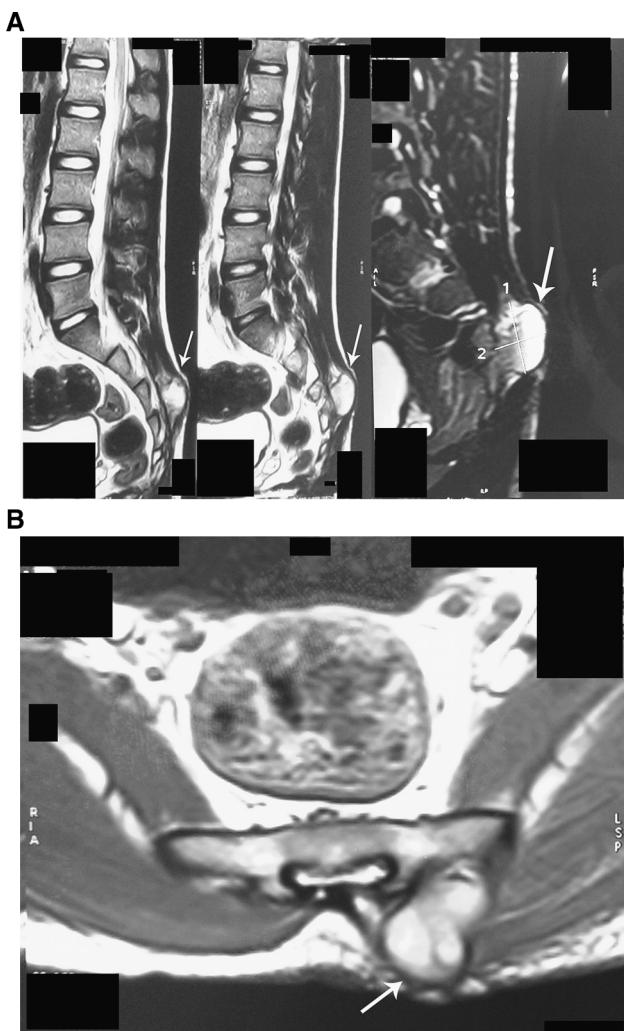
a Sagittal section of MRI showing 36×22 mm, well-circumscribed bony lesion protruding posteriorly at S3–S4 level without any anterior extension. b Cross section of MRI showing bony lesion arising from left of *midline* with thin hypointense rim and hyperintense *centre* indicating marrow
